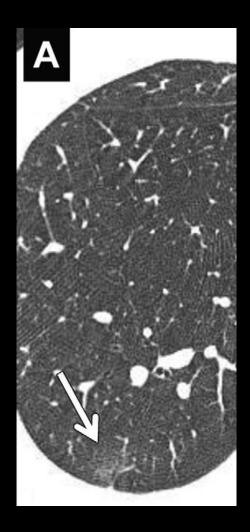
61-year-old woman with cancer not visible at previous CT screening (category 1). A, CT image shows no nodule in left lower lobe.
